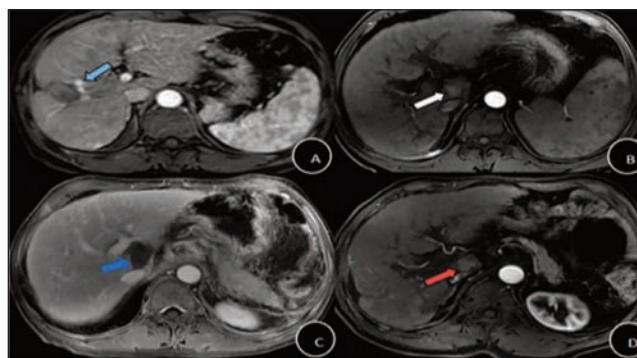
Seven days after RFA, the first follow-up MRI identified viable tumour at the ablation border, arterial-phase hyper-enhancement on CE-T1WI indicated residual tumour tissue (A). Preoperative MRI showed HCC with arterial-phase hyper-enhancement (CE-T1WI; B). Initial post-RFA MRI revealed no viable tumour in ablation area (C). At 30 months after RFA, viable tumour with arterial-phase hyper-enhancement was identified in the ablation area on follow-up MRI (D), and pathology confirmed it as local tumour progression.
